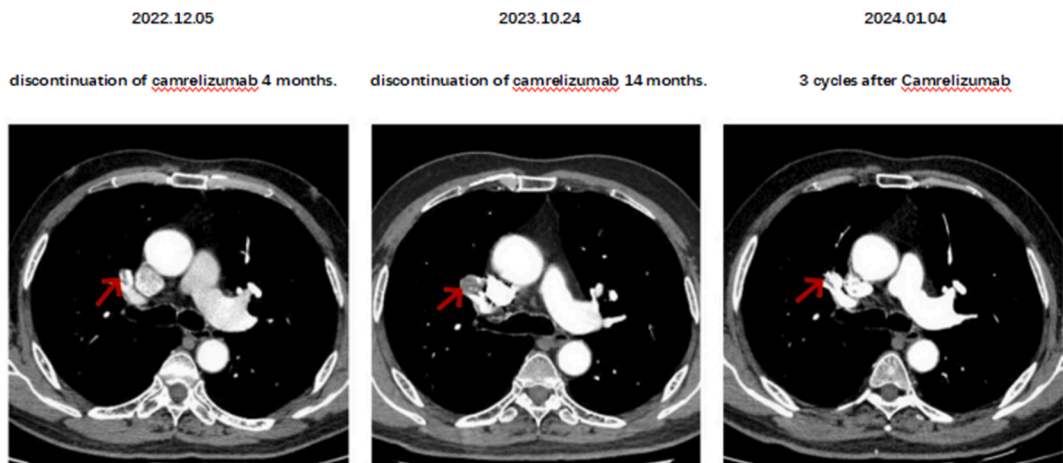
Computed tomography (CT) scan shows changes in the right lung hilar lymph nodes after discontinuing camrelizumab and continuing with camrelizumab.
